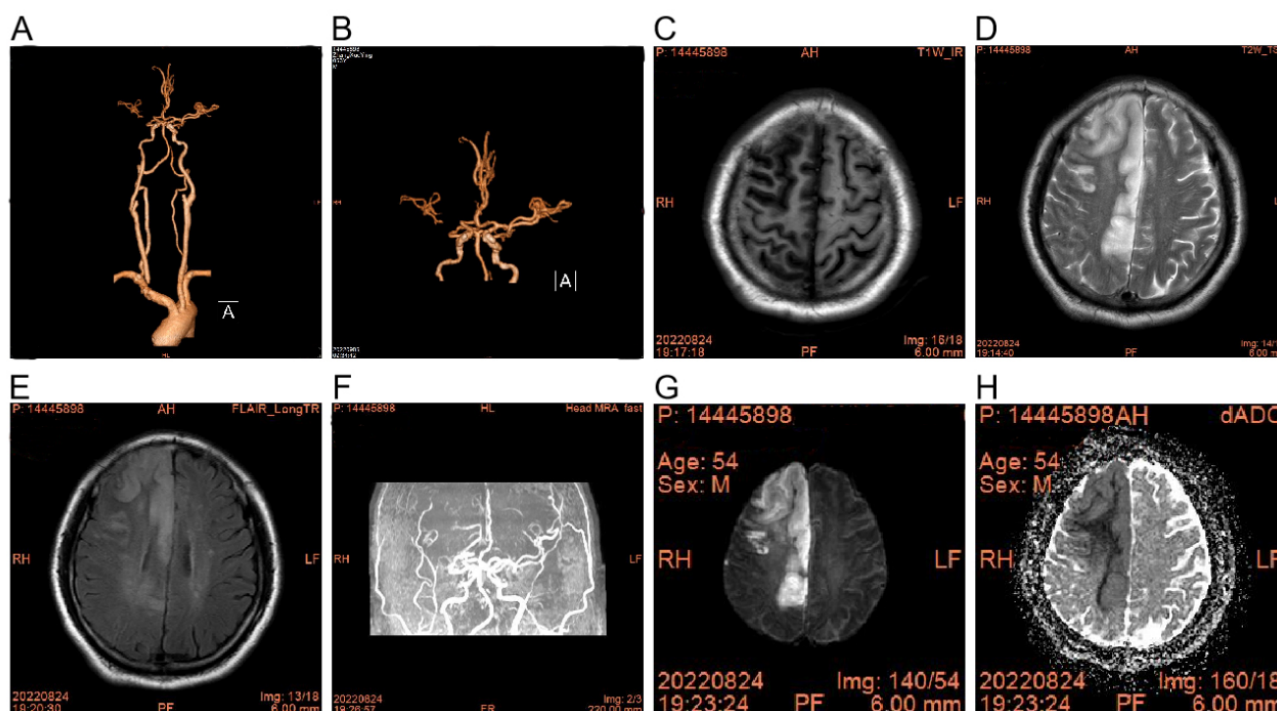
MRI of typical AIS sequences caused by anterior circulation stenosis. (A) CTA of head and neck with stenosis of anterior circulation vessels. (B) CTA of right middle cerebral artery stenosis. (C) T1WI sequence of right cerebral hemisphere infarction. (D) T2WI sequence of right cerebral hemisphere infarction. (E) FLAIR sequence of right cerebral hemisphere infarction. (F) TOF sequence of right middle cerebral artery occlusion. (G) DWI sequence of right cerebral hemisphere infarction. (H) ADC sequence of right cerebral hemisphere infarction. MRI, magnetic resonance imaging; AIS, acute ischemic stroke; CTA, computed tomography angiography; T1WI, T1 weighted image; T2WI, T2 weighted image; FLAIR, fluid attenuated inversion recovery; TOF, Time of Flight; DWI, diffusion-weighted imaging; ADC, Apparent Diffusion Coefficient.
